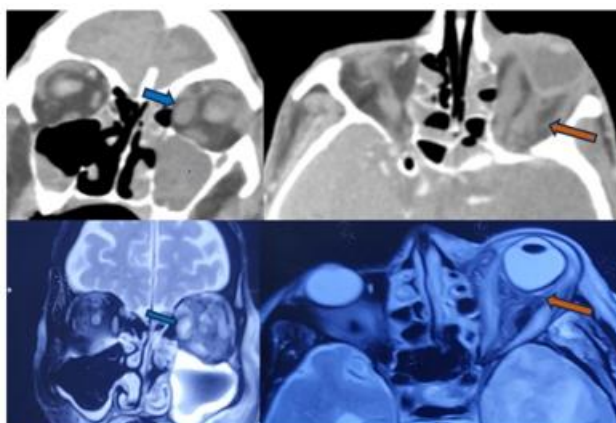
Plain CT and T2W MR images showing bulky extraocular muscles (blue arrow) and adjacent fat stranding (orange arrow). Let sided axial proptosis is also seen.
